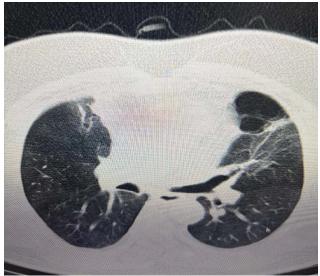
Emphysematous image on pulmonary CT scan
